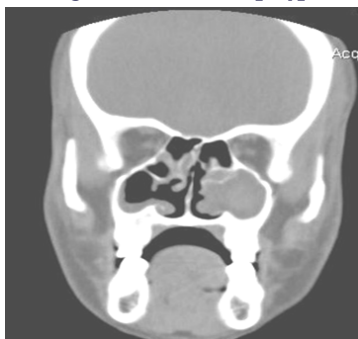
Figure no:6:Coronal CT-PNS Showing left antrochoanal polyp and right maxillary and ethmoid partial sinusitis
